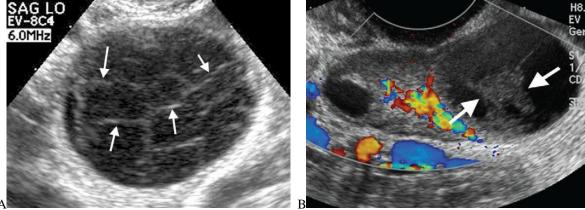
(A) Haemorrhagic cyst. Sagittal transvaginal US scan demonstrates a complex ovarian cyst with internal echoes. There is a reticular pattern to the internal echoes due to fibrin strands (arrows). (B) Haemorrhagic cyst. Sagittal transvaginal colour Doppler US scan shows a complex cystic mass within the periphery of the ovary.
